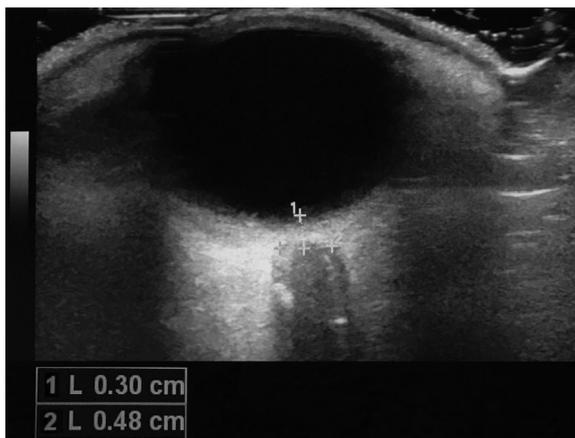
Sonographic image of an optic nerve sheath diameter measured 3 mm posterior to the retina.
